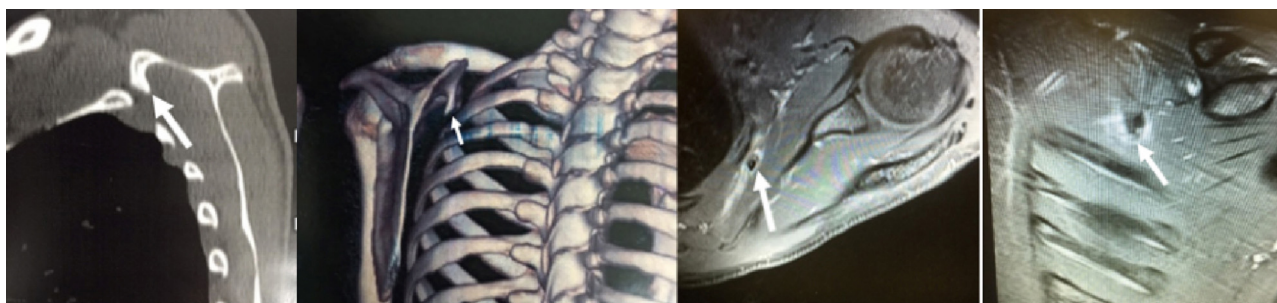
Tomography and magnetic resonance imaging showing a bone tumor in the superomedial region of the scapula.
